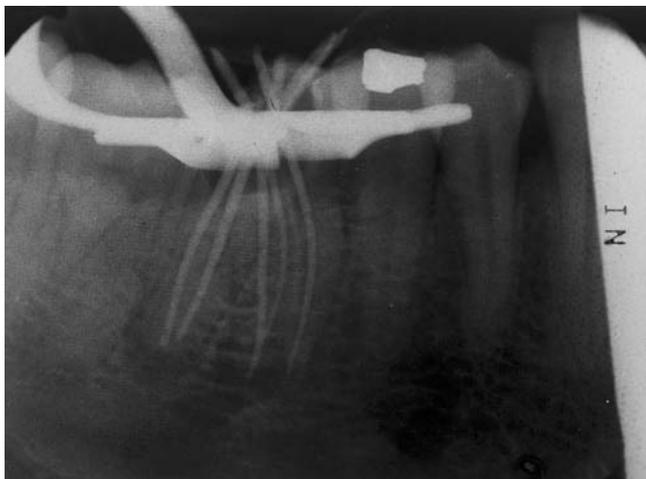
Gutta-percha cone fit radiograph confirming the middle mesial canal.
